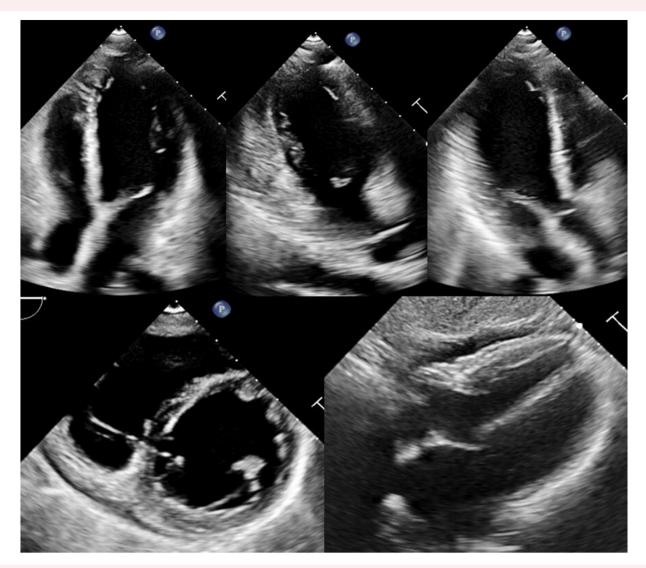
Echocardiography at 8-month follow-up (line above: apical four-, two-, and three-chamber views; line below, parasternal short axis at papillary muscle level and subcostal view) showing mild residual pericardial effusion.
